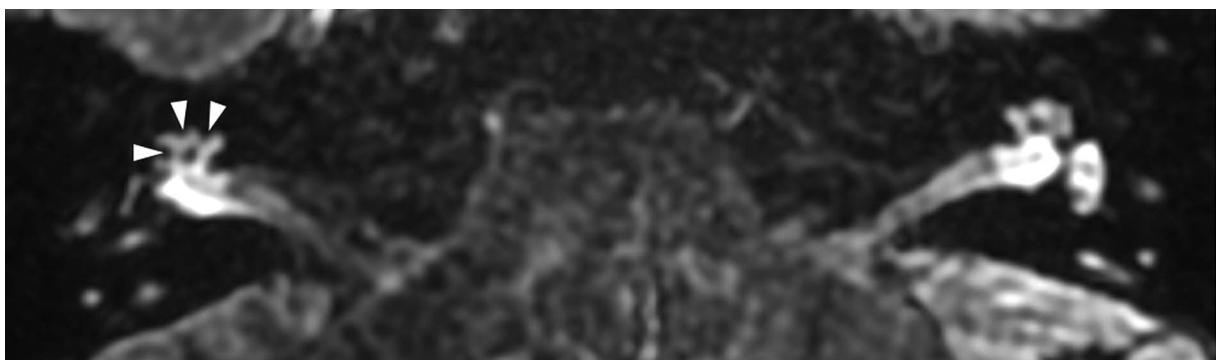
Magnetic resonance image of a 34-year-old female (patient #2) with right-sided clinically defined Ménière's disease. According to the Barath classification [11], it is an example case of grade 1 cochlear hydrops. Delayed-postcontrast 3D-FLAIR T2 axial image of both ears at the level of the cochlear modiolus. On the right side, a non-enhancing cochlear duct is visible as small dark nodules (marked with arrowheads) in the enhancing scala vestibuli; on the left side, normal left inner ear anatomy is presented for comparison
